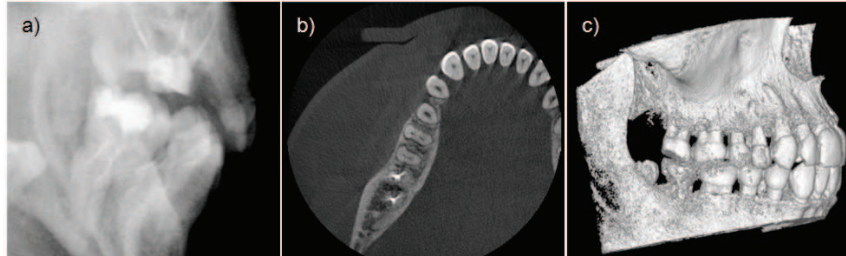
In the 3D viewing applications, the volume is typically represented either as individual slices or as a rendered 3D volume, which is basically generated by stacking the slices. Example of images related to CT scan a) one of the projection images, b) a single reconstructed axial slice and c) a rendered 3D volume from the same region.
